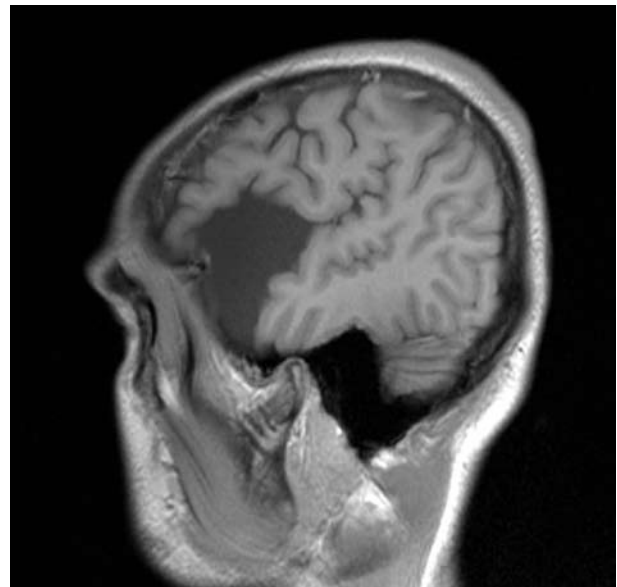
T3-weighted magnetic resonance image (sagittal plane) showing an ovoid-cystic lesion in the middle cranial fossa. The mass effect on the right temporal and frontal lobe (with hypoplasia) determined by the arachnoid cyst is visible.
